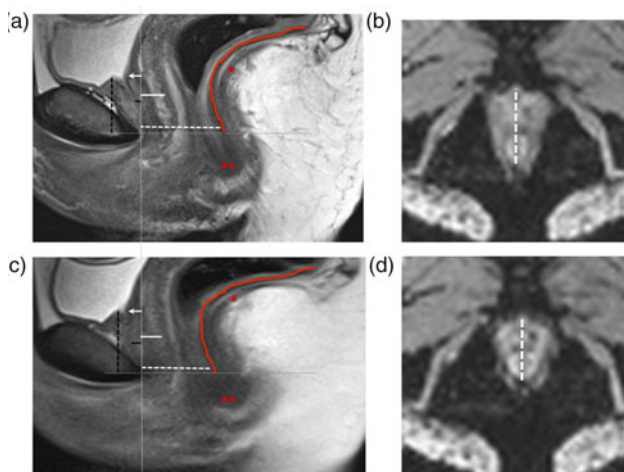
Sagittal (a) and axial (b) MR images acquired at rest and during maximal voluntary contraction of the pelvic floor muscles (c, d). The posterior rectal wall (contour) and the *levator plate* (asterisk) moved superiorly and anteriorly, as well as the anorectum (double asterisk). The anterior-to-posterior diameter of the *levator hiatus* decreased 5 mm (dashed line on the sagittal and axial images), in response to the contraction of the puborectal muscle.
